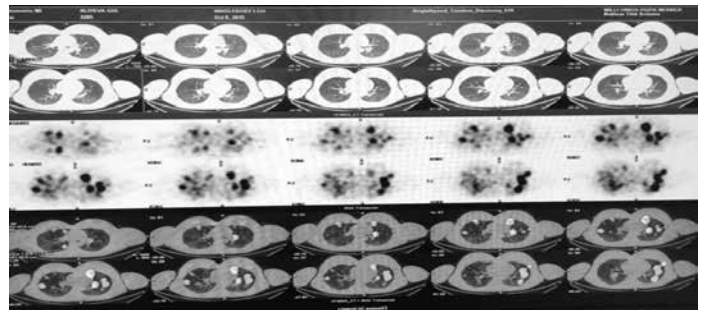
Comparative pictures of lungs CT, scintigraphy SPECT-CT.
